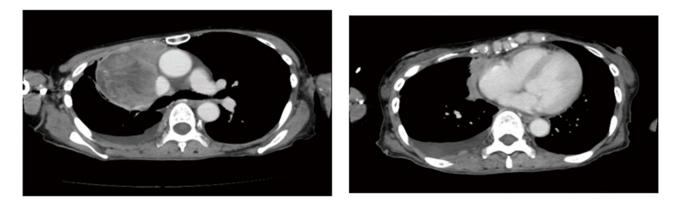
Computed tomography reveals an anterior mediastinal tumor, 78 mm in diameter, at the carina level (A)(left), and right pleural effusion and pleural dissemination at the heart level (B)(right).
